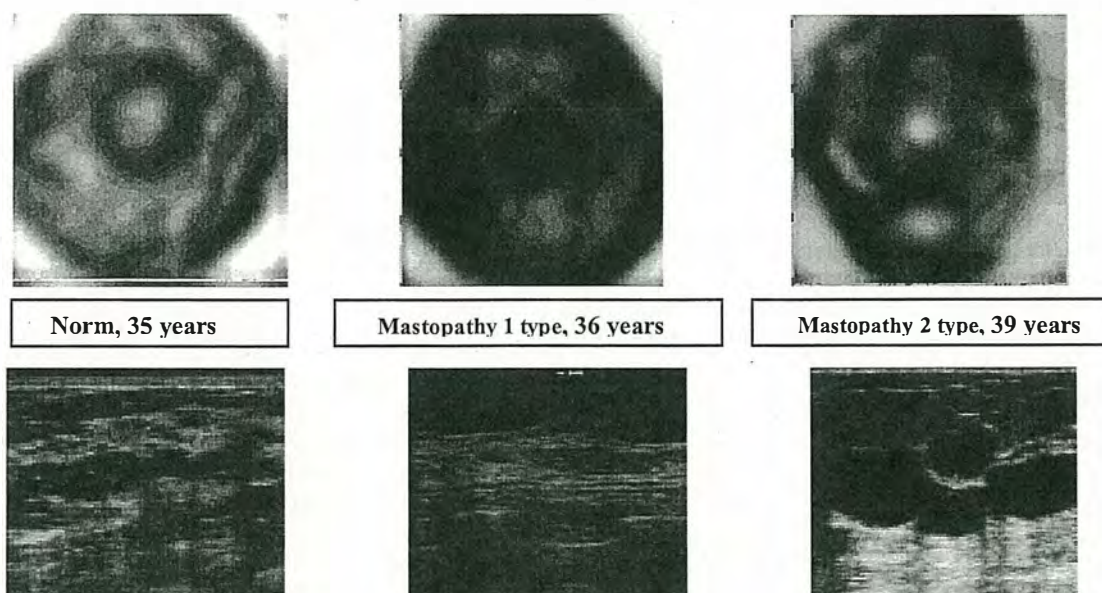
Electro impedance and ultrasonic images of mammary glands in norm and during mastopathy (the 2nd scanning level, 50 kHz)
